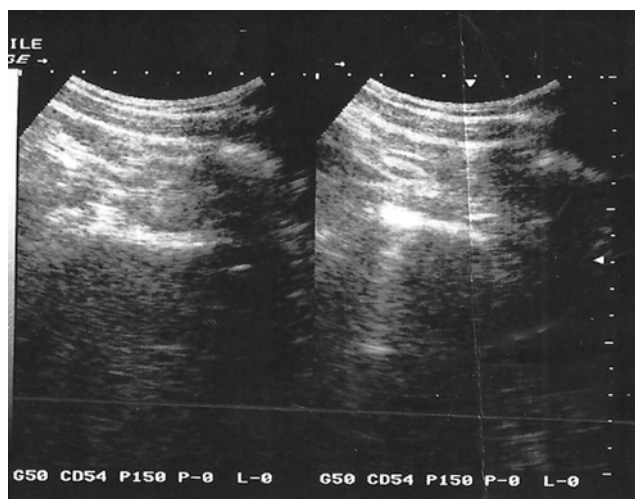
Ultrasound: linear hyperechogenic area in the uterine cavity measuring 13 mm.
